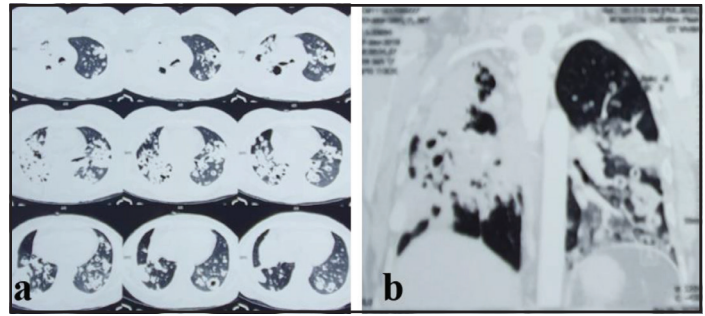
CT chest showed bilateral nodule with confluent shadow with thick-walled cavity prominent more in mid to lower lobe.
